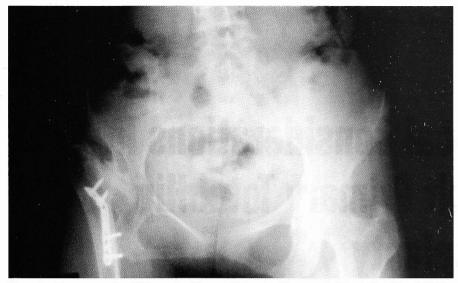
The preoperative AP X-ray of a 39 year old female with congenital dysplasia of the right hip. The right femur was treated with a femoral osteotomy at age 8.
